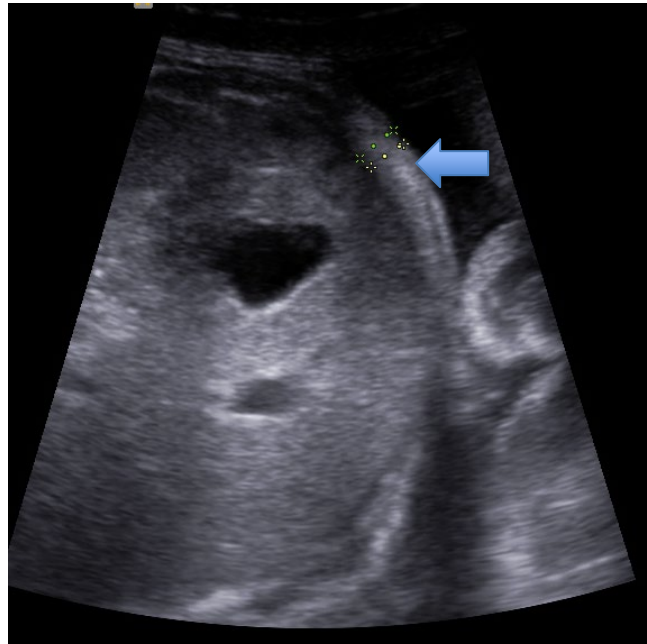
Ultrasound image of fetal abdominal fat mass (AFM; blue arrow). Participant image used with permission.
